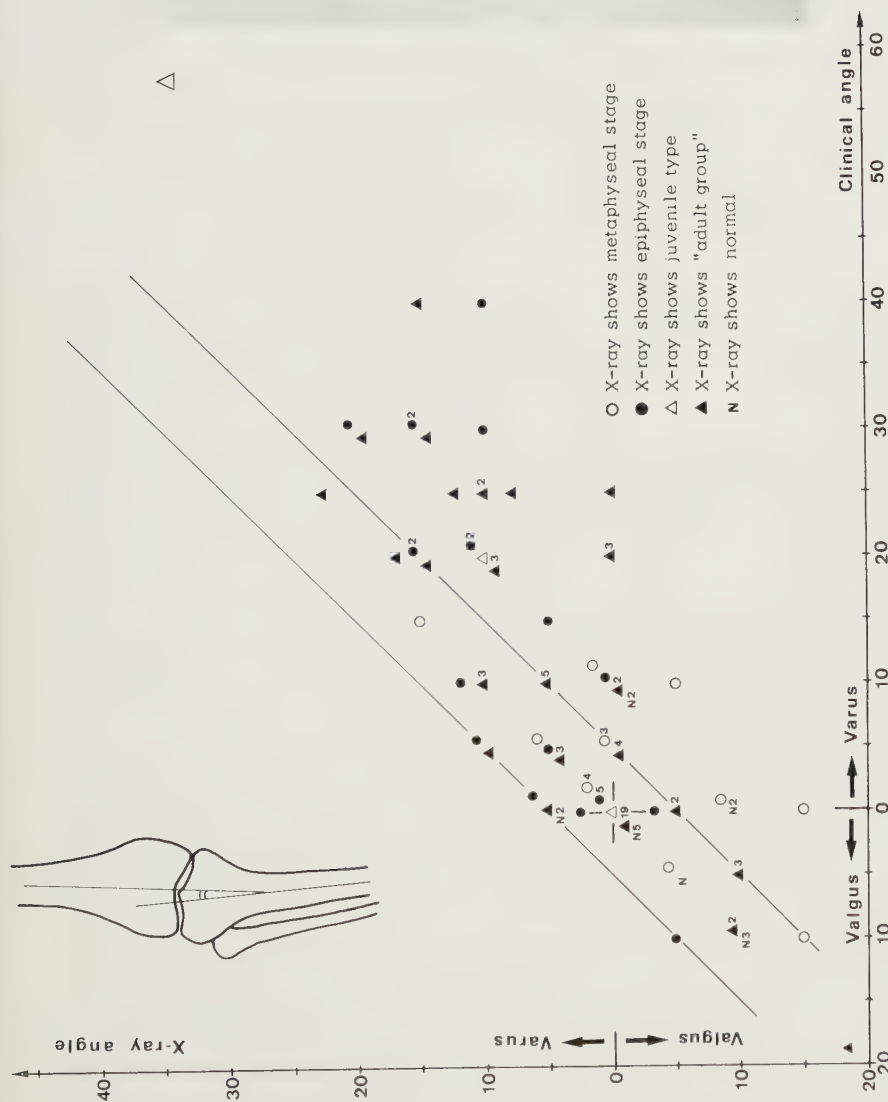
The relation between the clinical angle and the radiographic angle 1 in 119 knees.
